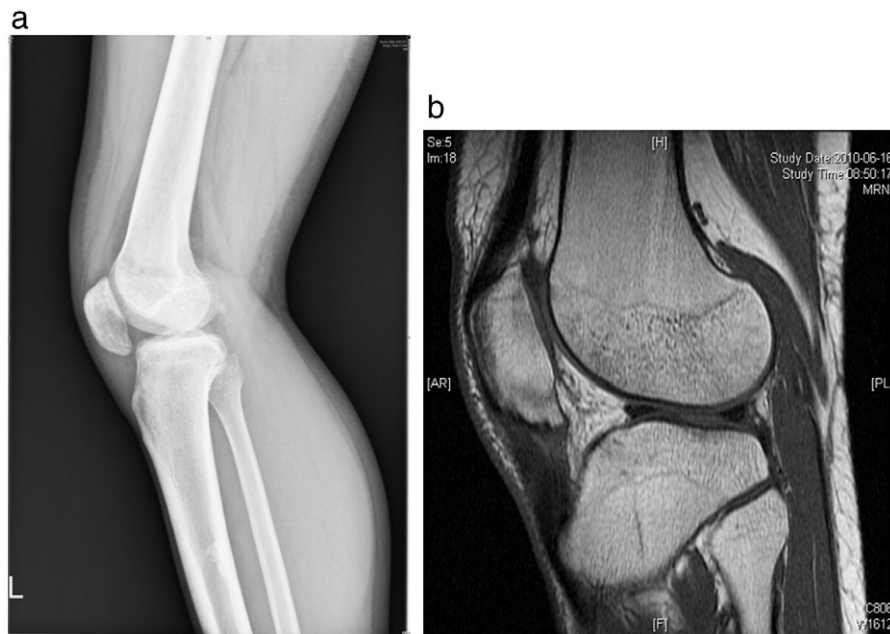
a Six months after patellar fracture, a lateral radiograph showed severe patella infera. b MRI showed that the patellar tendon was thickened and shortened.
